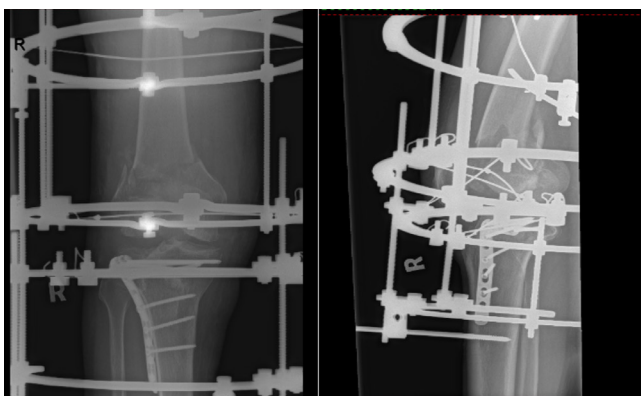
Postoperative radiograph of the distal right femur including knee joint and proximal tibia shows the holding olive wire compress the intercondylar fracture fragments.
